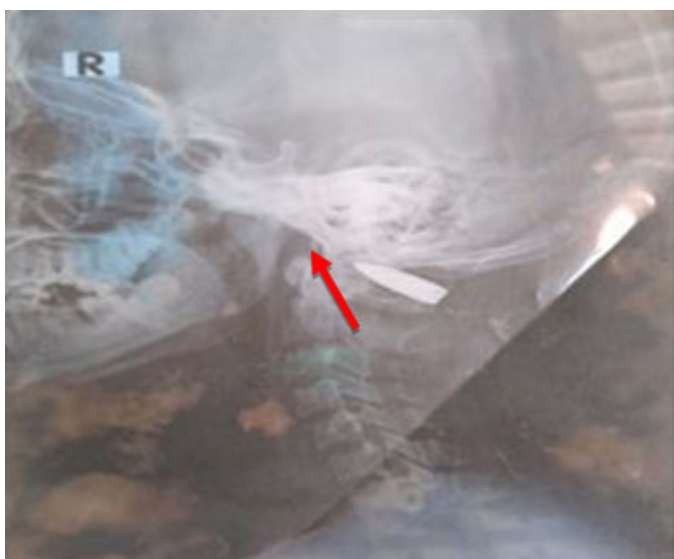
Standard cranio-cervical X-ray showing the presence of a projectile at the level of the occipito-atloid joint (red arrow).
